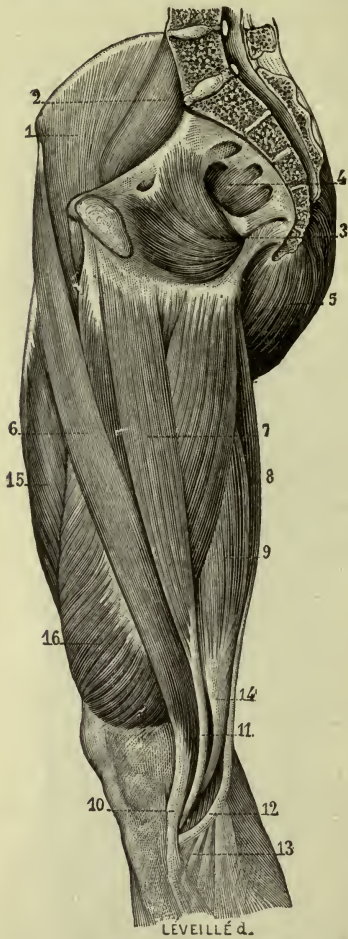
MEDIAL ASPECT OF THE THIGH AND PELVIS.
